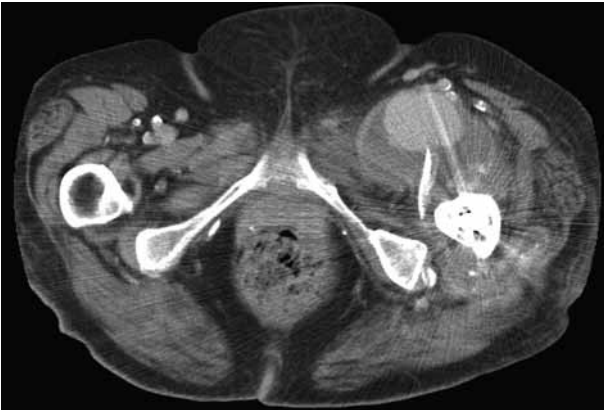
CT scan showing a pseudoaneurysm of the profunda femoris artery caused by a bony fragment from the lesser trochanter, with haematoma.
